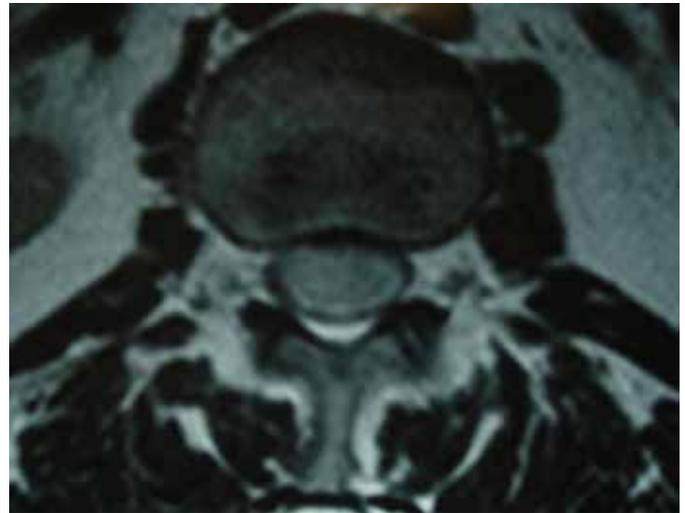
Axial T1-weighted MR images at the level of the L1-L2 revealing intradural tumor.
